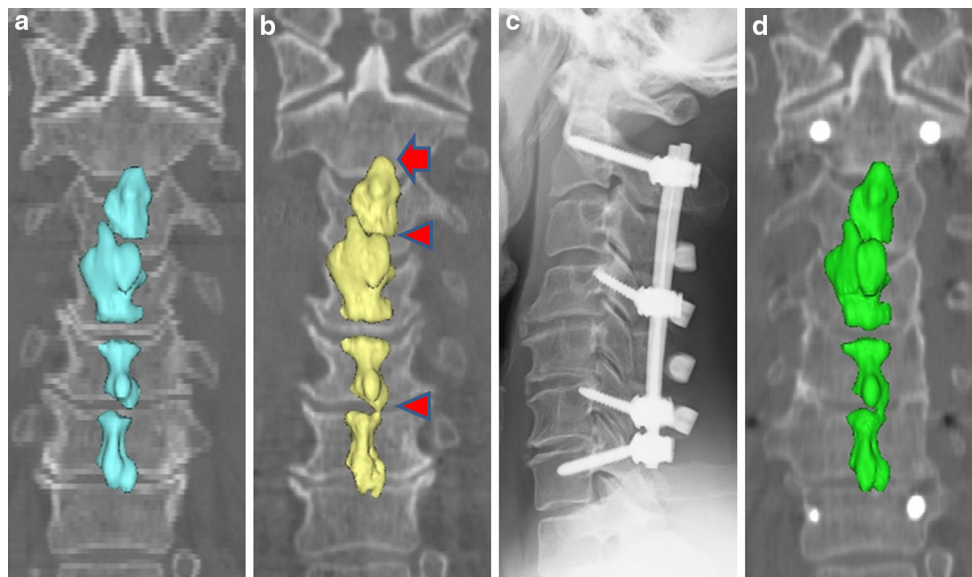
a A 3D model of mixed-type OPLL showing the C3–C6 level at the initial visit. b A preoperative 3D model of OPLL showing progression at both the cranial portion of the OPLL (arrow) and C3/C4, C5/C6 intervertebral area (arrowhead). c A plain radiography
